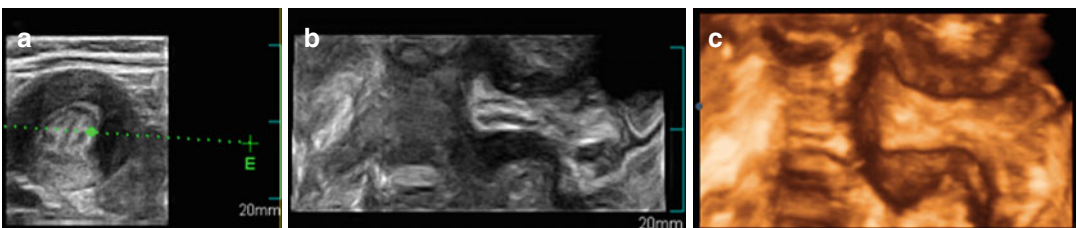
(a) Two-dimensional and (b, c) three-dimensional ultrasound scans demonstrate the hypertrophic pyloric stenosis
